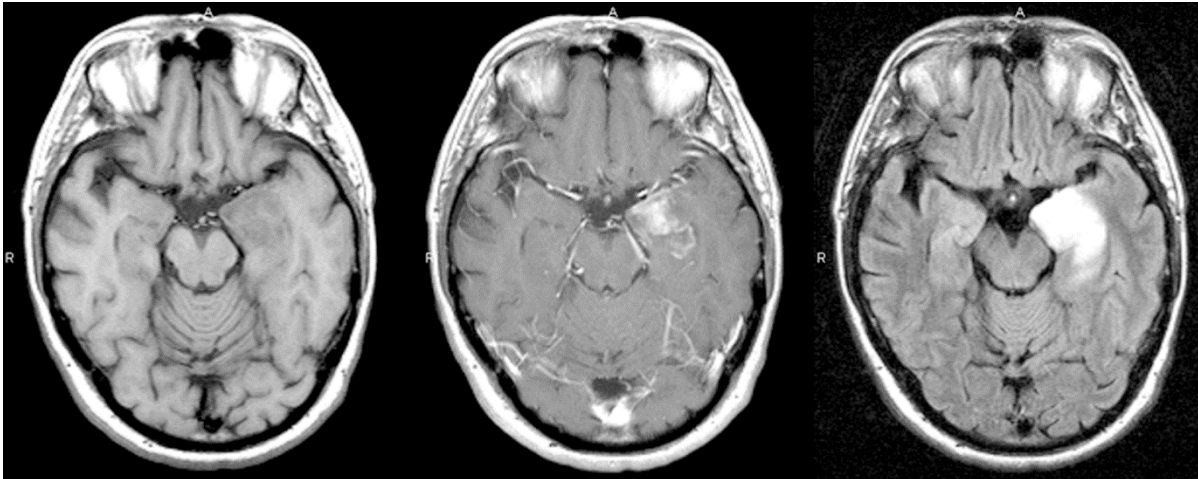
Herpes encephalitis. (A) Axial T1W precontrast administration. (B) Axial T1 postcontrast administration. (C) Axial FLAIR imaging.
